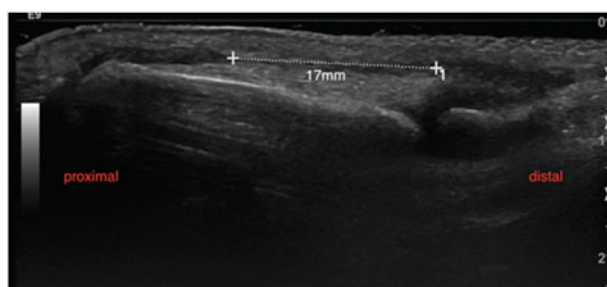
Preoperative sonography of the injured right thumb revealing an avulsion of the EPL tendon with a gap of 17 mm in full extension.
